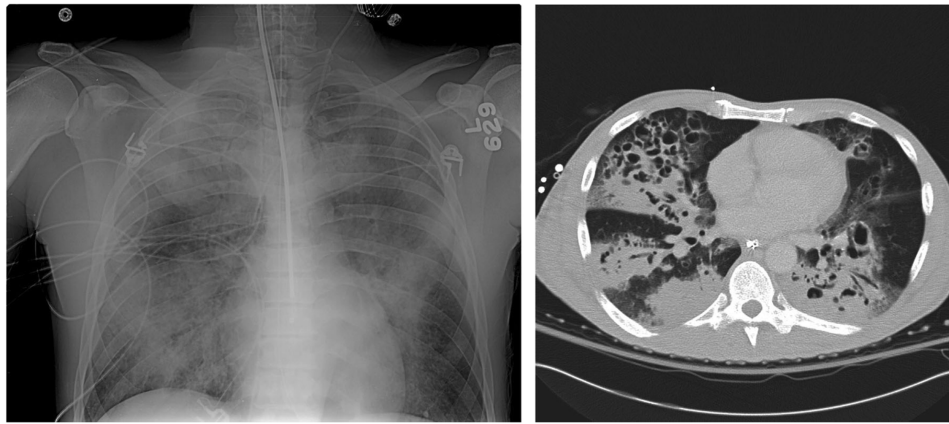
Chest x-ray and CT scan of the chest of a young patient with community-associated methicillin-resistant *Staphylococcus aureus* pneumonia. Reprinted from [13], with permission from the American College of Chest Physicians.
